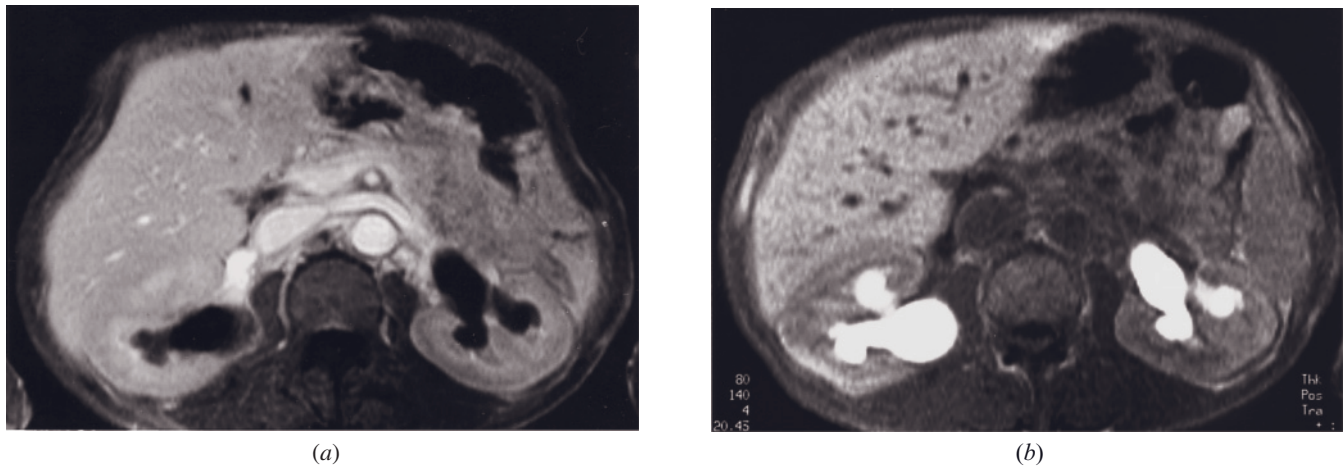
Delayed excretion in high-grade obstruction. T1-weighted 2-min postgadolinium fat-suppressed SGE image (*a*) demonstrates severe dilatation of the renal collecting system secondary to bladder cancer. SGE image (*b*) obtained 24 h later demonstrates delayed excretion of gadolinium.
